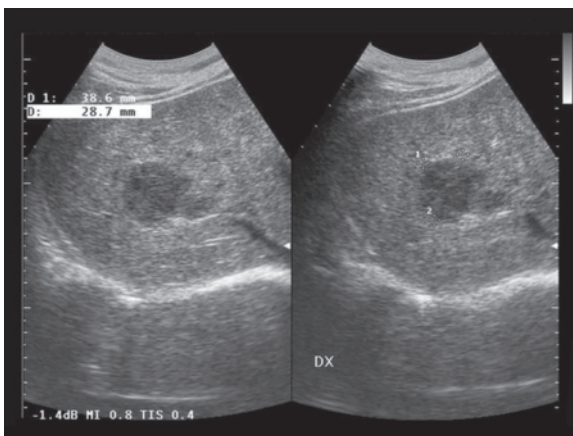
b Hemangioma of the liver. Heterogeneous hypo-anechoic mass (a). The appearance is nonspecific but the axial CT scan in the portal phase shows progressive centripetal opacification of the lesion (b, arrows)
